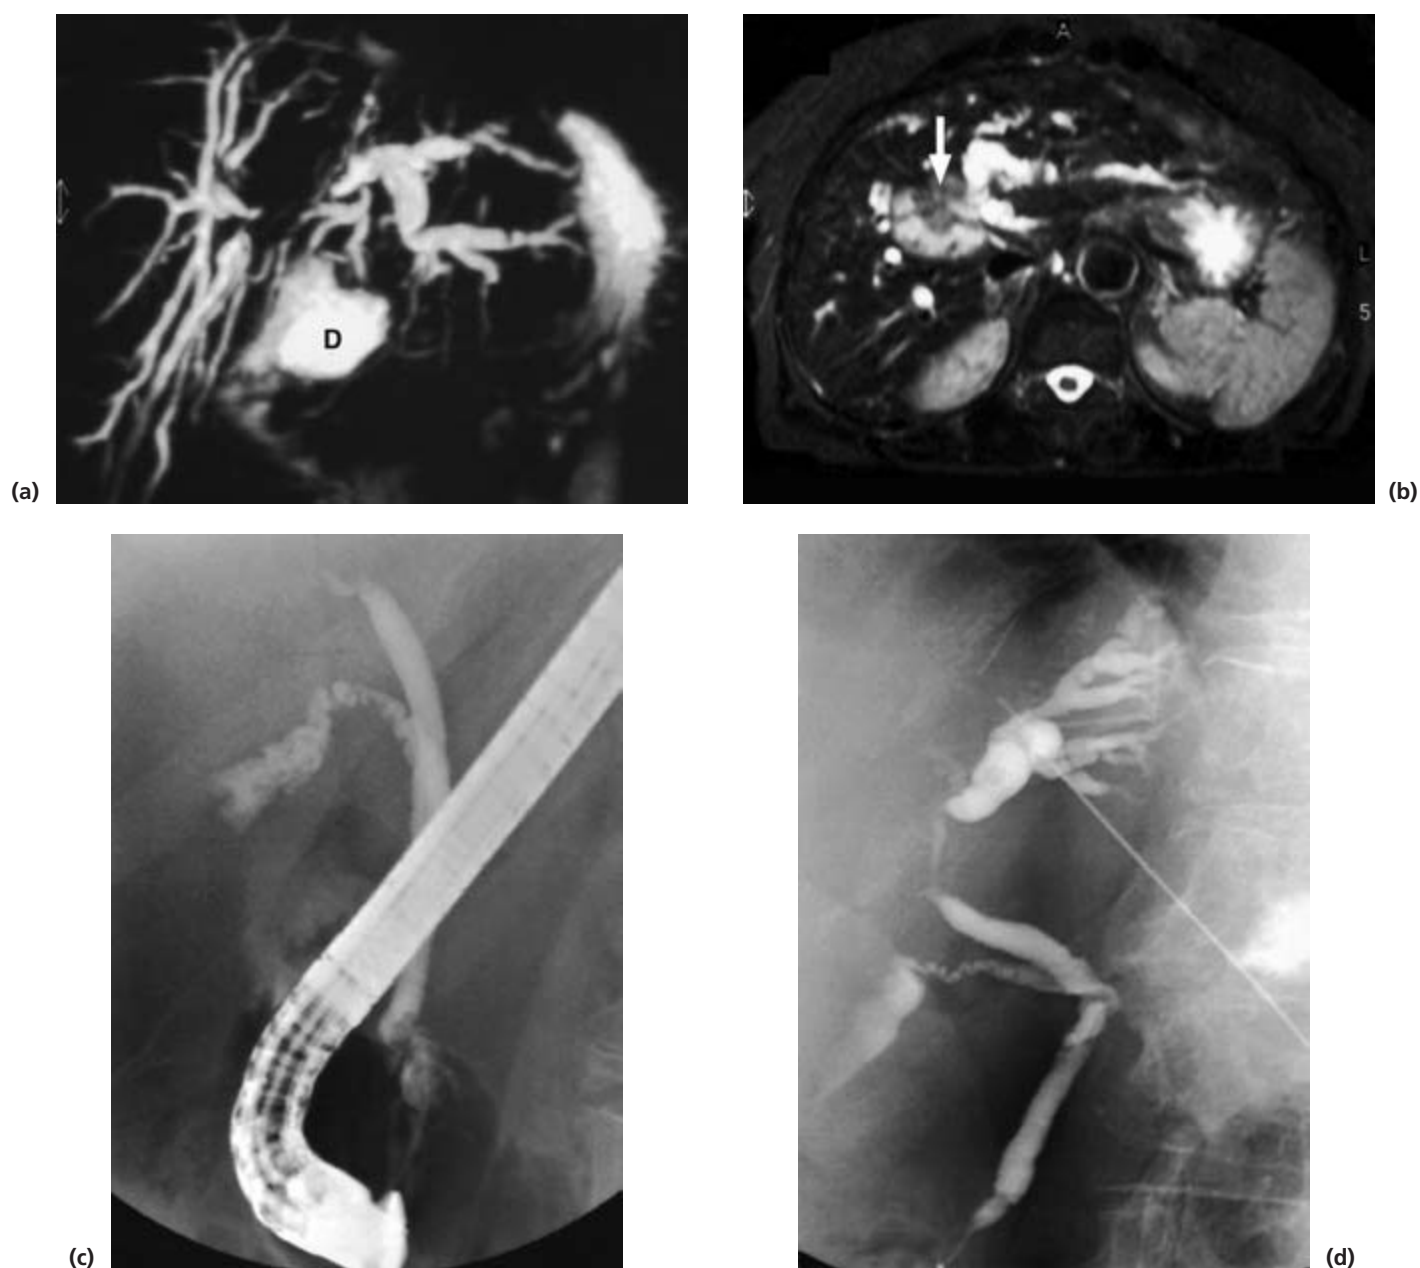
A 75-year-old woman presenting with cholestatic jaundice. Ultrasound showed dilated intra-hepatic ducts, a hilar mass and a normal common bile duct. (a) MRCP shows dilated intra-hepatic ducts with at least three segments obstructed in the right lobe and the left hepatic system obstructed at the hilum. If non-surgical drainage is to be done, these appearances favour drainage of the left- rather than the right-sided system (D, duodenum). (b) MRI scan shows a mass in the liver (arrow) above the hilum. (c) Non-operative drainage was chosen since the patient was considered inoperable. ERCP shows a normal common duct with a hilar structure. A stent could not be placed. (d) Following on the MRCP appearances, the left-sided duct system was chosen for percutaneous cholangiography and a stent inserted.
